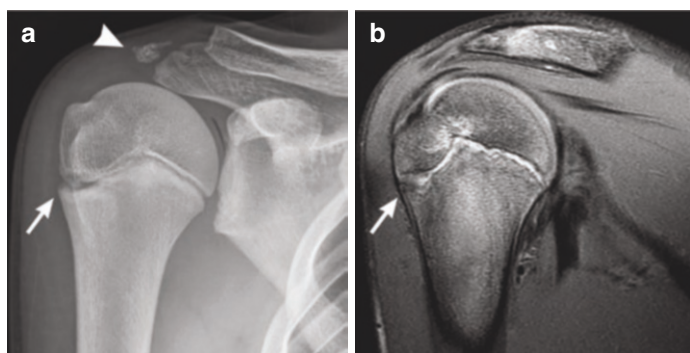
(a) AP radiograph: physeal widening and irregularity in the lateral proximal humeral physis are visualized (arrow). Note the well-corticated acromial ossification center (arrow head). (b) On MR arthrogram: Physeal widening and irregularity, bone marrow edema and effacement (arrow) [13]
